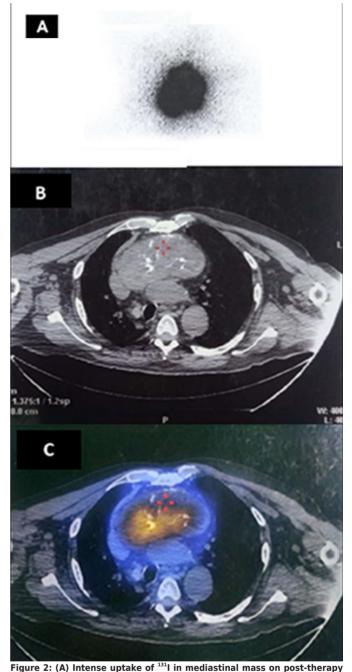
(A) Intense uptake of Iodine-131 in mediastinal mass on whole body scan. (B) Soft tissue density retrosternal mass in axial CT. (C) Iodine-131 uptake in retrosternal mass on axial fused SPECT/CT.
